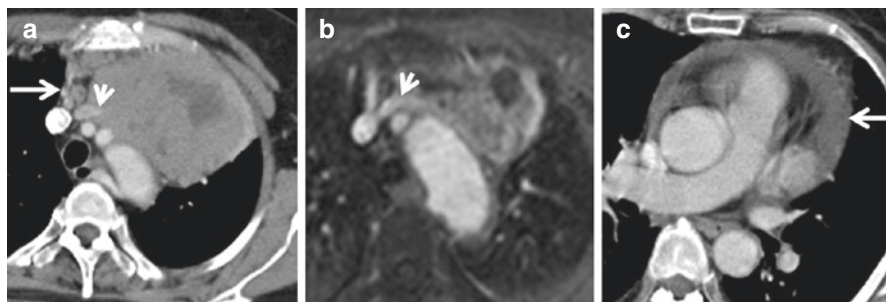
A 60-year-old woman with thymic carcinoid. (a) Enhanced CT shows a plaque-shaped mass measuring 10.8 cm in maximal diameter, at the level of the aortic arch in the left anterior mediastinum, with lobulated contour, which presents heterogeneous moderate enhancement (mean densitometric value, 67HU) and nonenhanced cystic changes inside. The left brachiocephalic vein is encased in the tumor and narrowed by the tumor invasion (short arrow). Prevascular lymphadenopathies are showed clearly (long arrow). (b) The mass presents heterogeneous moderate enhancement and nonenhanced cystic changes inside on fat-suppressed T1-weighted MR imaging. The left brachiocephalic vein is encased in the tumor and narrowed by the tumor invasion (short arrow). (c) Pericardial effusion is found on the following images (arrow)
